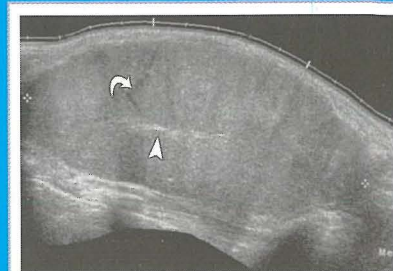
A juvenile fibroadenoma seen on ultrasound as a well circumscribed, homogeneously hypoechoic mass (straight arrow) within the fibroglandular breast tissue (*), with the pectoralis muscle deep to the mass (curved arrow).
